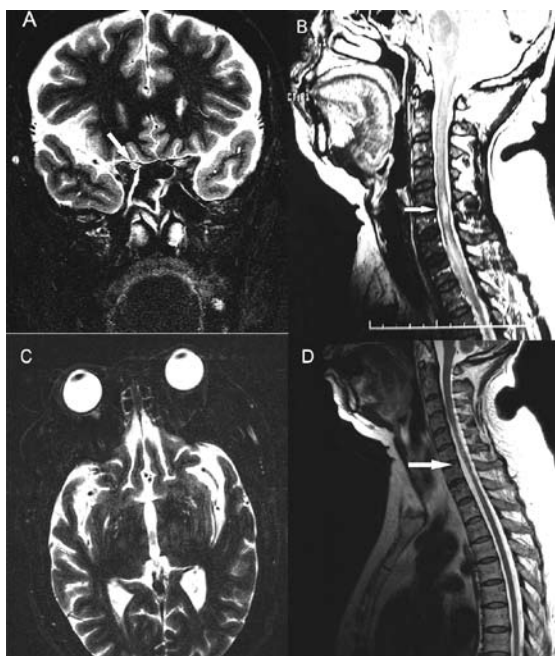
Magnetic resonance imaging findings: A) A coronal T2-weighted image showing hyperintense signals in the right optic nerve (arrow). B) A sagittal T2-weighted image showing a cervical cord lesion extending from C6 to T3 (arrow). C) An axial T2-weighted image showed no abnormal findings. D) A sagittal T2-weighted image showing spinal cord atrophy and a lesion extending from C3 to T2 (arrow).
